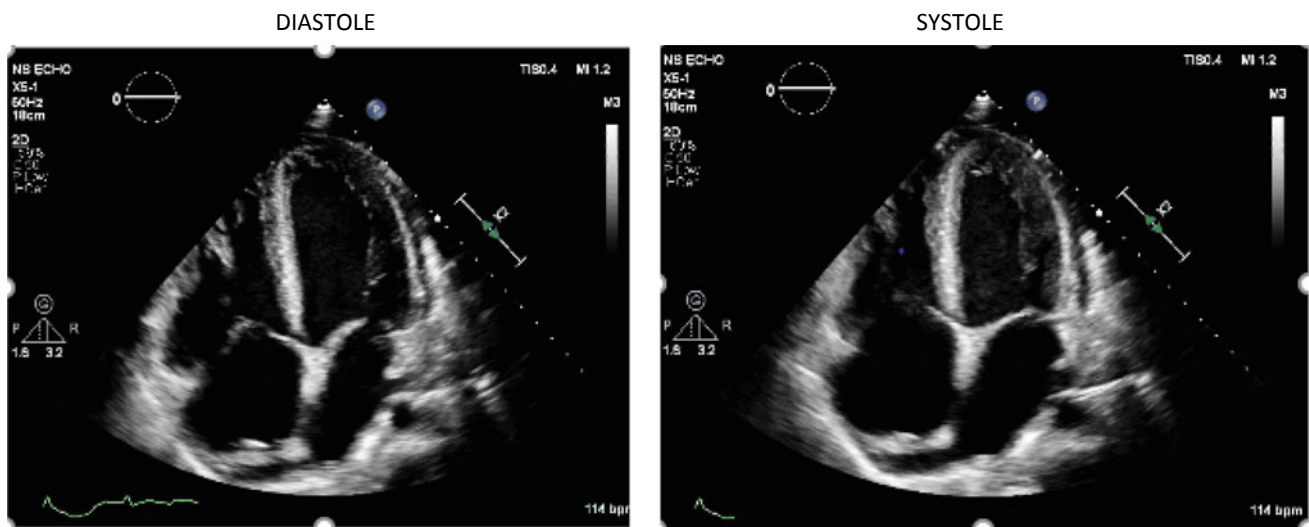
Transthoracic echocardiogram shows global left ventricular hypokinesia with estimated LVEF of 35%. Apical four-chamber view
